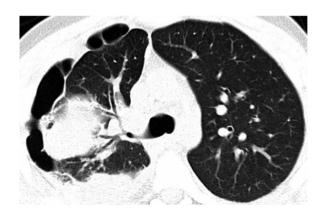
Thoracic CT showing right pleural effusion, septate pneumothorax and multiple nodules in both lungs.
